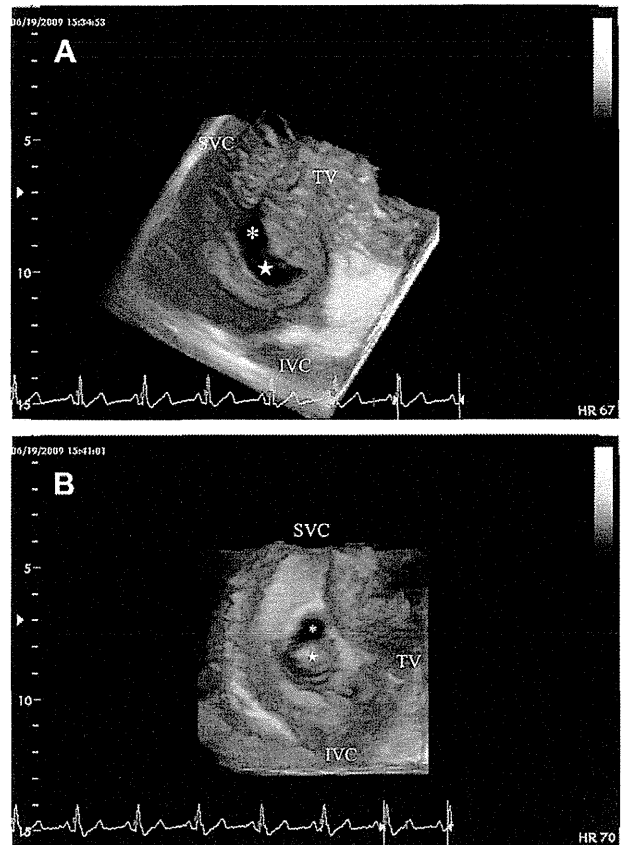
Three-dimensional TTE of the secundum-type ASD (*asterisk*) with an atrial septal aneurysmal (ASA) viewed from the right atrium. (A) The ASA (*white star*) was dropped out from the left parasternal approach (B) but was clearly visualized from the right parasternal approach. IVC, Inferior vena cava; SVC, superior vena cava; TV, tricuspid valve.
